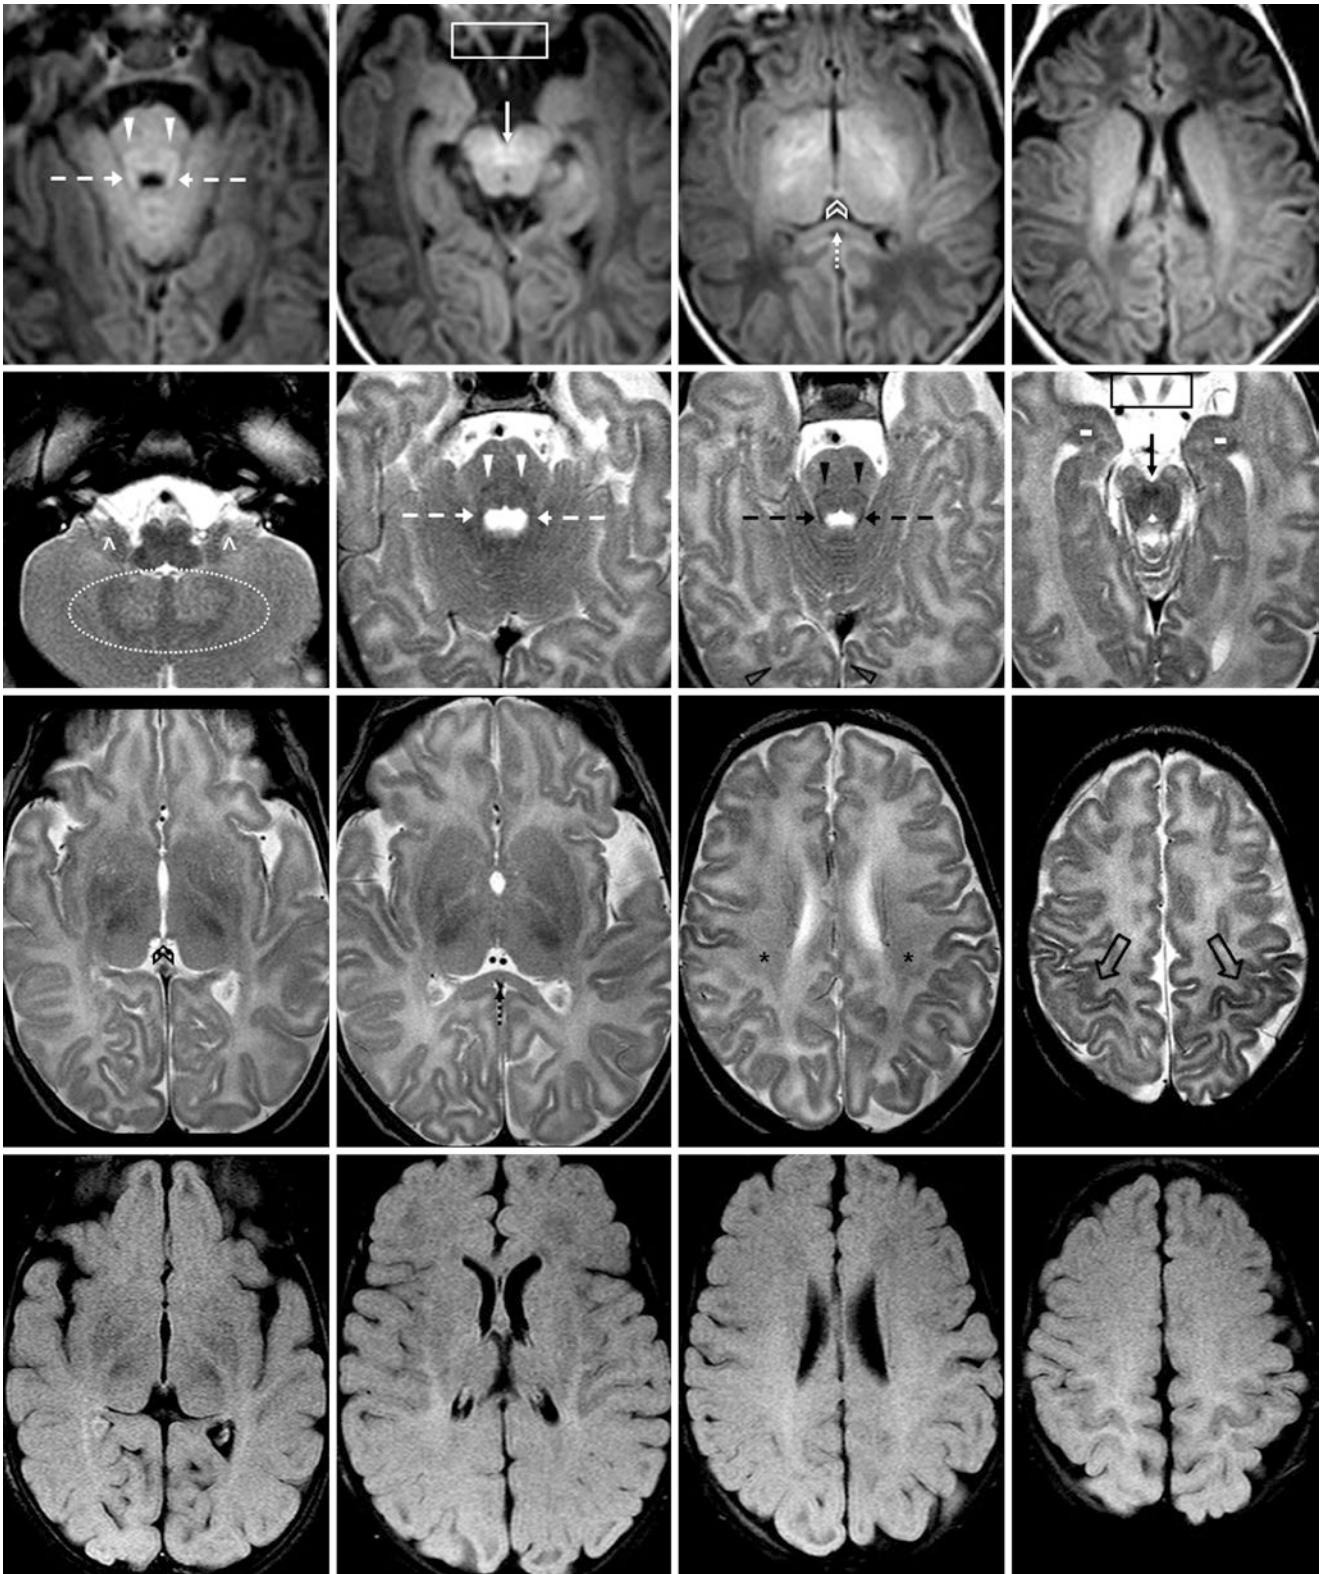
A 7-week-old with leg weakness and a negative 3T MRI of the brain and spine. *Top row:* GE T1WIs show myelinating superior cerebellar peduncles (*dashed arrows*), their decussation (*thin arrows*), medial leminisci (*arrowheads*), optic nerves (*box*), and HC (*chevron*). The PLIC is still quite bright. *Second row:* On SE T2WIs, note T2-dark signal of the same structures, as well as a darkening ventral brainstem, deep cerebellar white matter and nodulus (*dotted oval*), flocculi (*^*), and optic nerves. Also, note the T2-dark amygdalae (*white dashes*). *Third*
